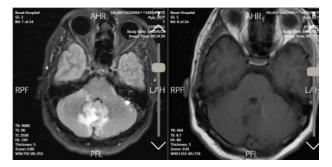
Brain MRI revealed a ventriculoperitoneal shunt, evidence of previous surgery, and multiple lesions in the posterior fossa.
